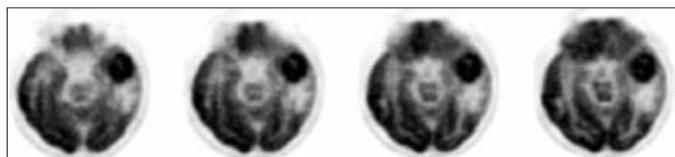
February 2010 axial FDG- PET imaging showing a hypermetabolic lesion in the left temporal lobe which is surrounded with hypometabolism due to the oedematous changes
